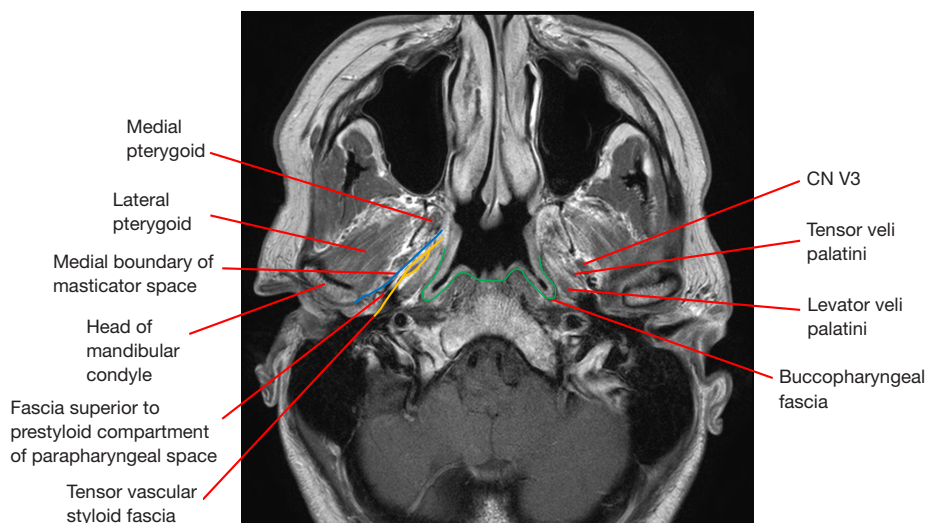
Axial MRI image at the level of the TMJ. The proposed mechanism for extravasation during TMJ arthroscopy is that fluid will extravasate along the superior belly of the lateral pterygoid muscle within the masticator space, then, by an unclear mechanism, the irrigant will exit the masticator space and travel along the tensor vascular styloid fascia within the prestyloid compartment parapharyngeal space. TMJ, temporomandibular joint.
